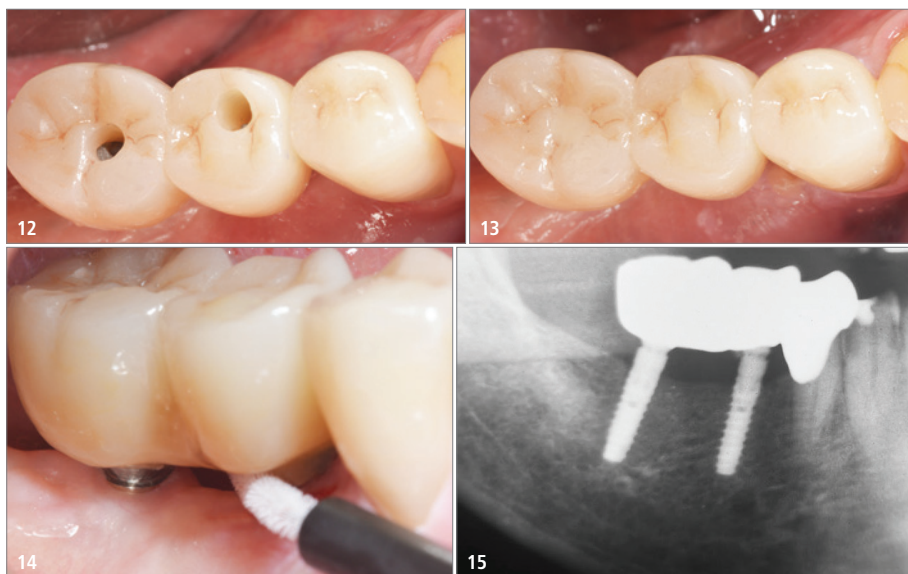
The prosthesis on teeth 45 and 46, before... – Fig. 13: ... and after occlusal closure (Empress Direct, Ivoclar Vivadent)... – Fig. 14: ...shows interdigital patency. – Fig. 15: Radiograph check-up after 14 months.
